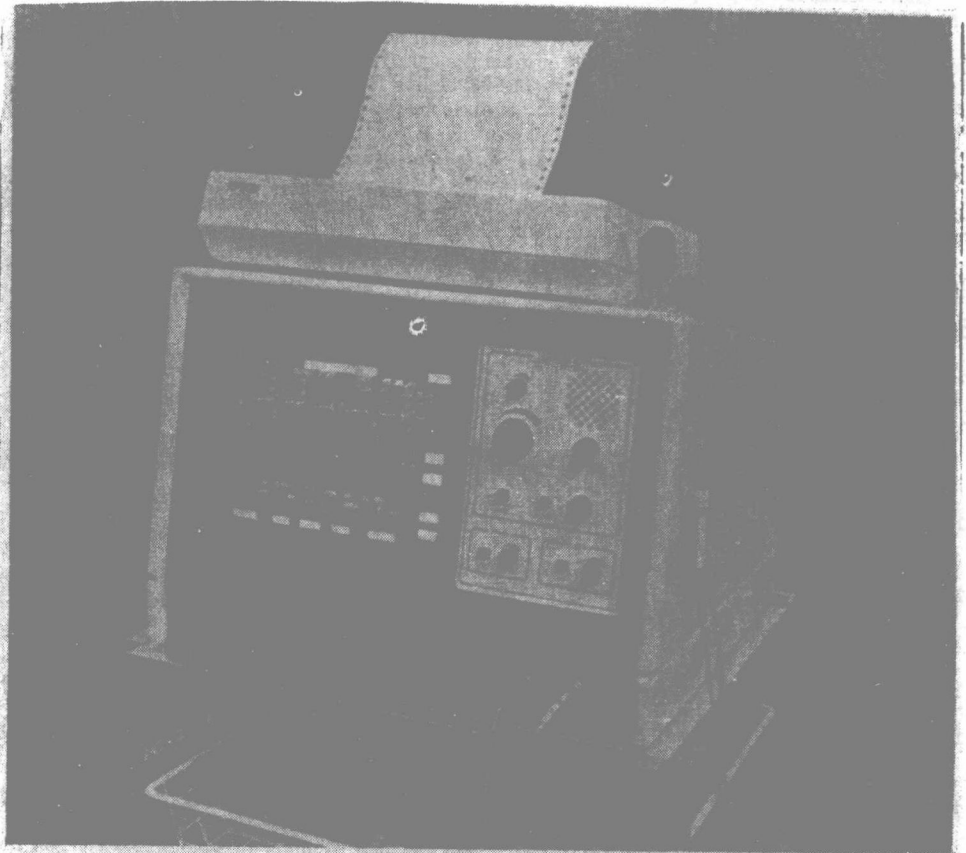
Dedicated Doppler instrument with A-mode and computational capacity to measure cardiac output (Vingmed, Oslo, Norway).
